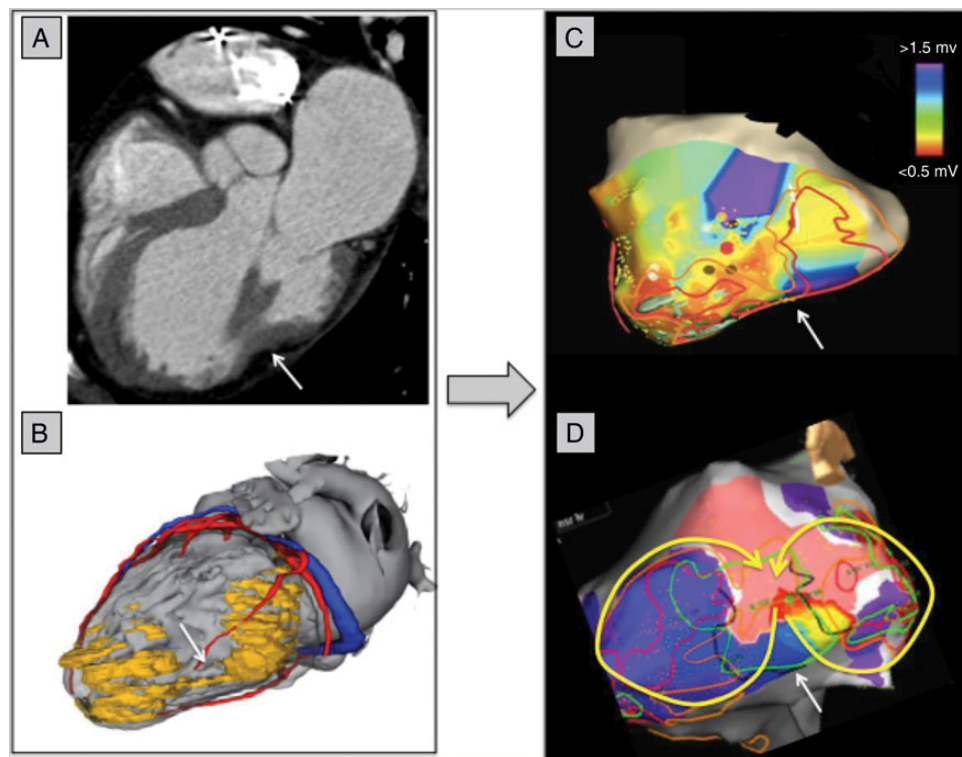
Patient 1 with post-myocarditis subepicardial only scar (lateral view). (A) Multidetector computed tomography image of the left ventricle, showing two lateral zones of focal wall thinning with an anatomical epicardial isthmus in between (white arrow). (B) Three-dimensional mesh (derived from merged information of MDCT and MRI) made using Music software (INRIA, Nice and CHU Bordeaux, France) with coronary artery system in red, coronary venous system in blue, and two zones of scar (wall thinning) in yellow with an isthmus in between (white arrow). (C) Epicardial bipolar voltage map, using the EnSite™ Velocity™ system (St Jude Medical). Purple is normal voltage >1.5 mV, green is borderzone >0.5 to <1.5 mV, and grey is dense scar <0.5 mV. Brown LAVA dots are manually tagged and seen inside the anatomical isthmus (white arrow). Successful ablation site is tagged in red. (D) Activation map of the clinical incessant VT, showing a figure-of-eight circuit through the isthmus. Ablation is performed during VT and the first application at the narrow VT exit site stopped the VT.
